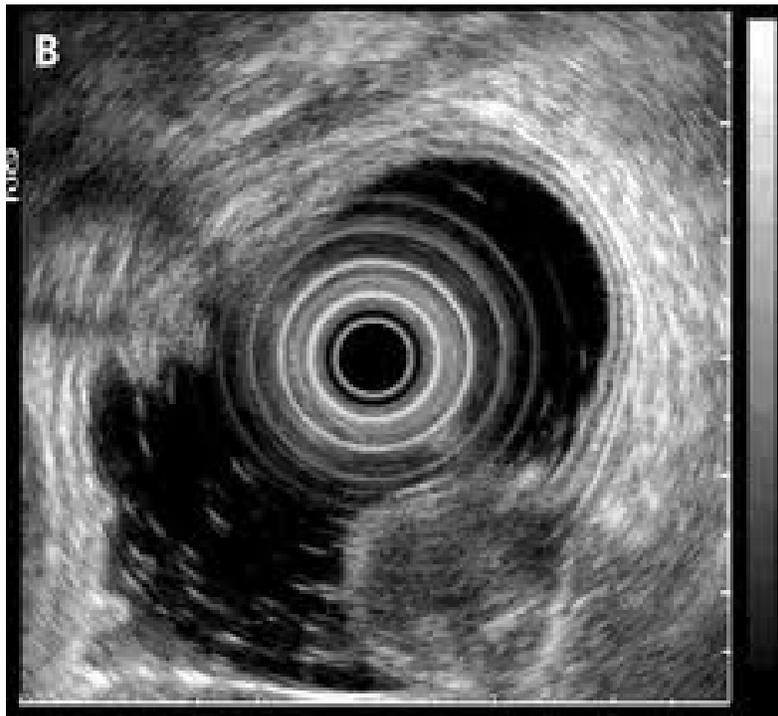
Endoscopic ultrasonogram showing five layers .
